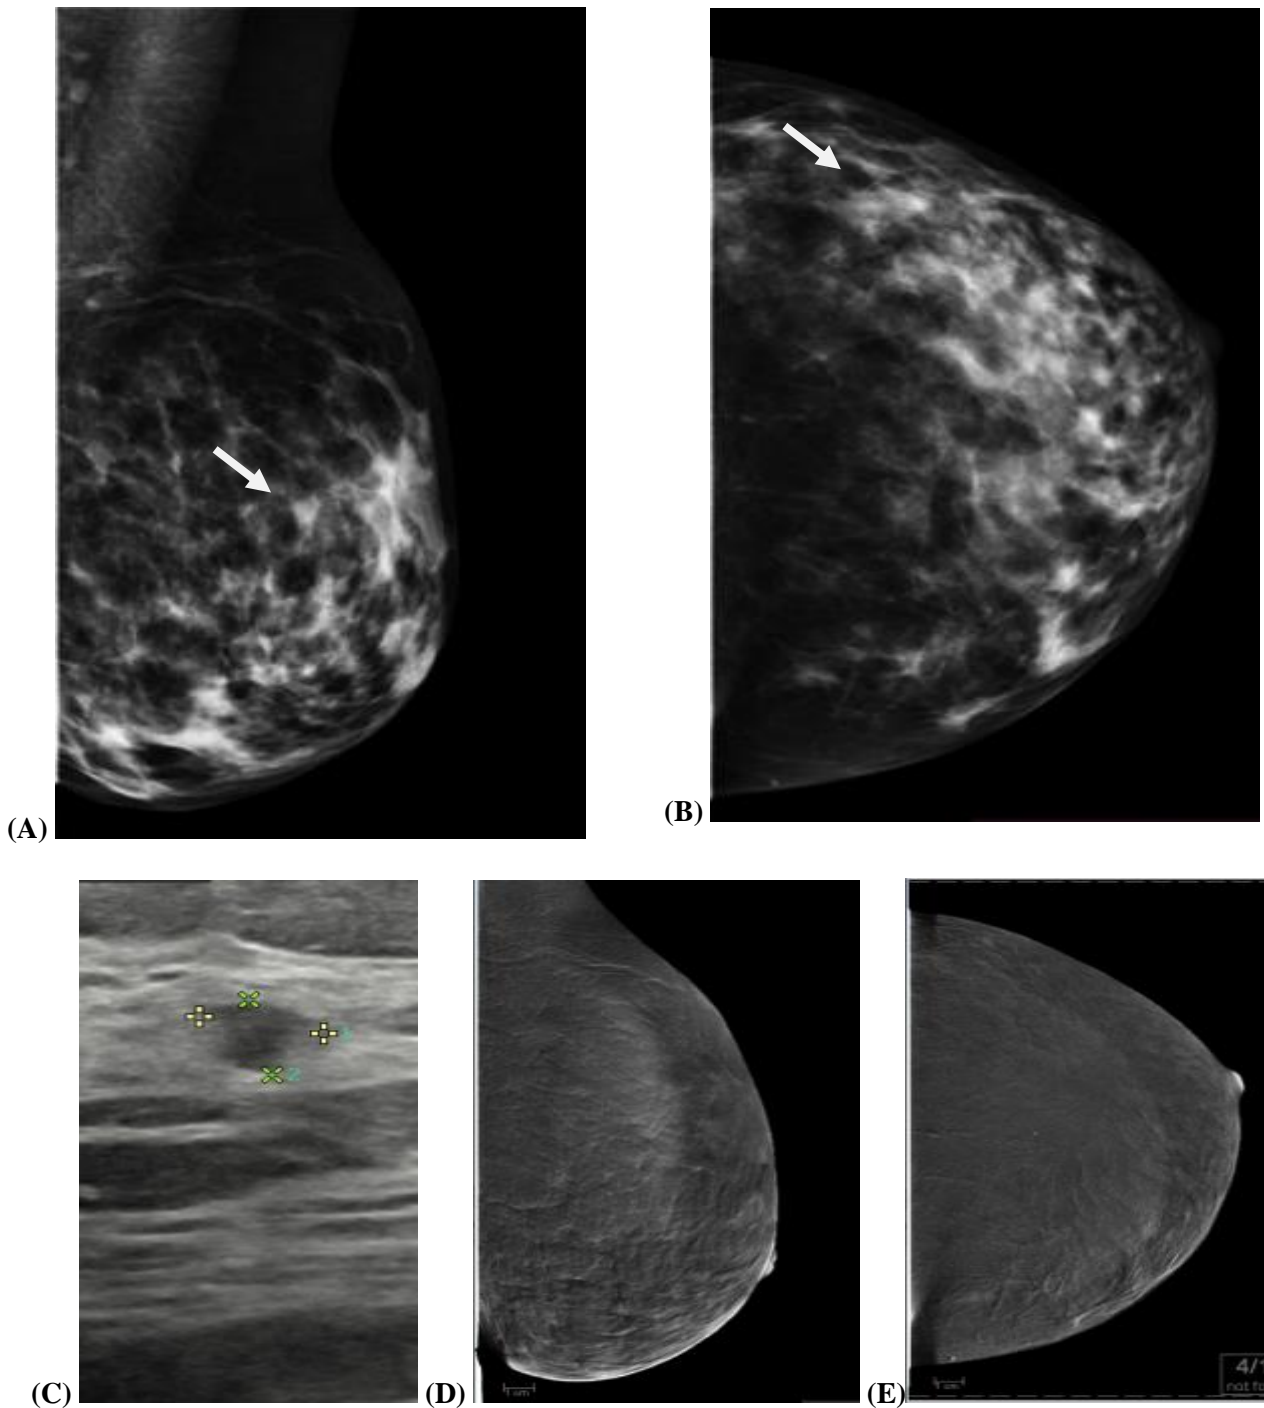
A 52-years-old female on screening. (A-B): DM: MLO and CC views of the left breast revealed upper outer ill-defined partially circumscribed lesion obscured by condensed glandular tissue. (C): ultrasound revealed a small well-defined lesion with an angular border taller more than wider categorized as BI-RADS 4. (D-E): CC views of CEDM of right breast revealed no enhancement of the lesion. The lesion was downgraded and categorized as BI-RADS 2. Pathology result was fibroadenoma.
